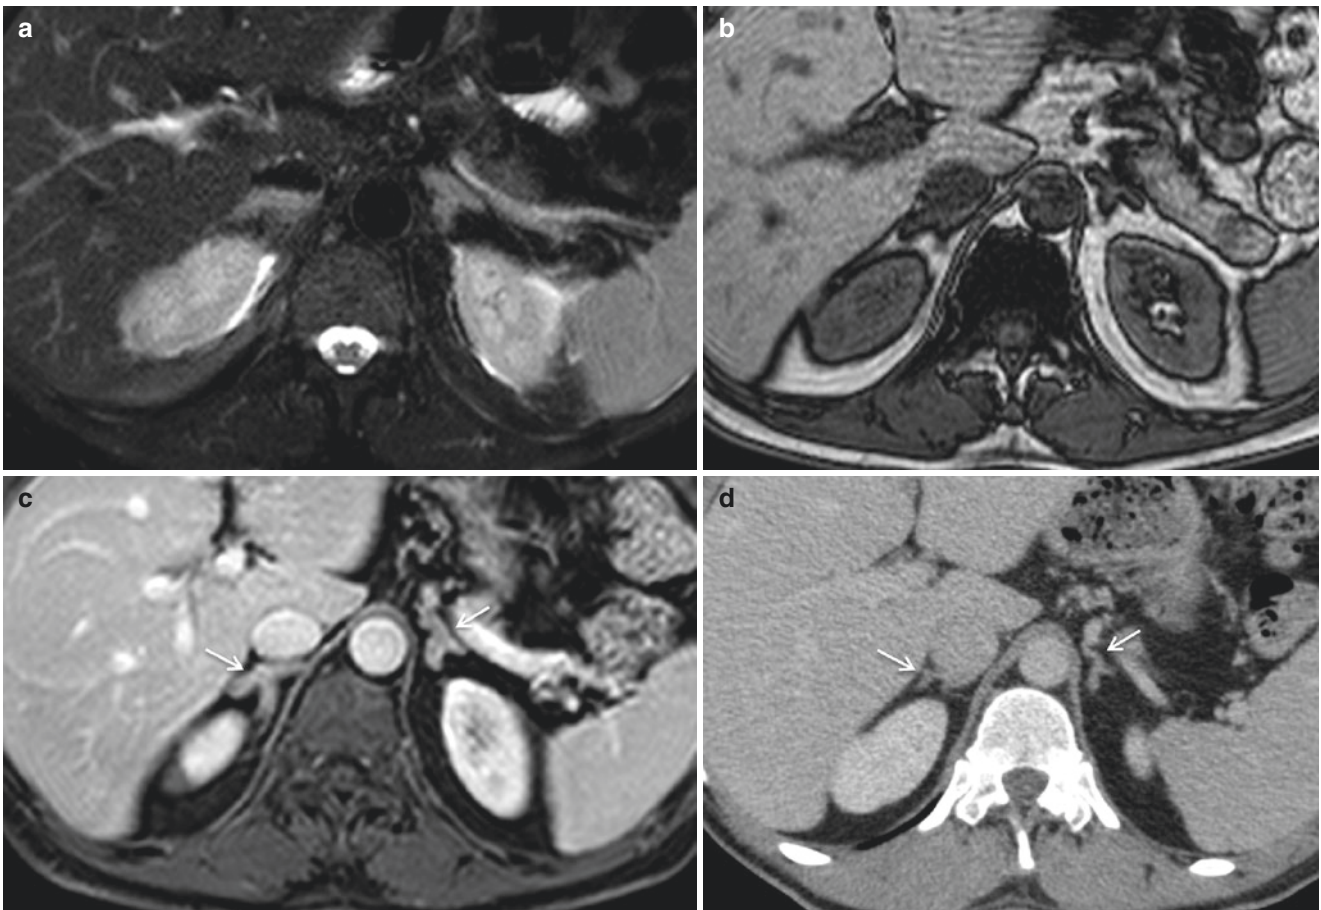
ACTH-dependent Cushing's syndrome. Axial T2-weighted (a), out-of-phase T1-weighted (b), and post-gadolinium fat-suppressed T1-weighted (c) images showing diffuse enlargement of both adrenal
